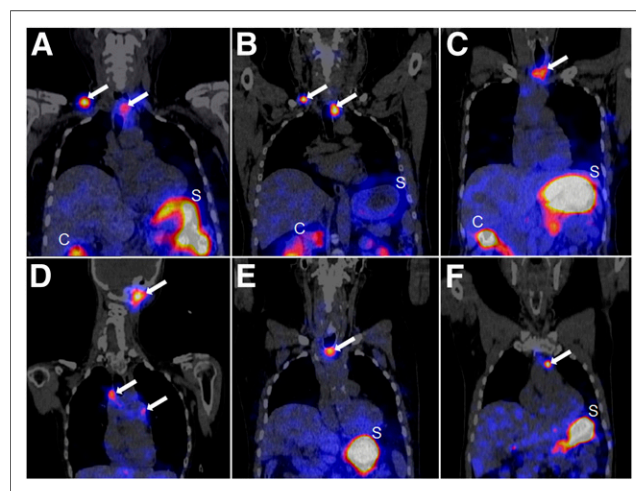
^{177}Lu -PP-F11N SPECT/CT scans in coronal orientation 24 h after injection. In all 6 patients (patients 1–6 [A–F, respectively]), several tumors were visualized with SPECT (white arrows). Minimal diameter of detectable tumor was 8 mm (patient 6 [F]). C = colon; S = stomach.
